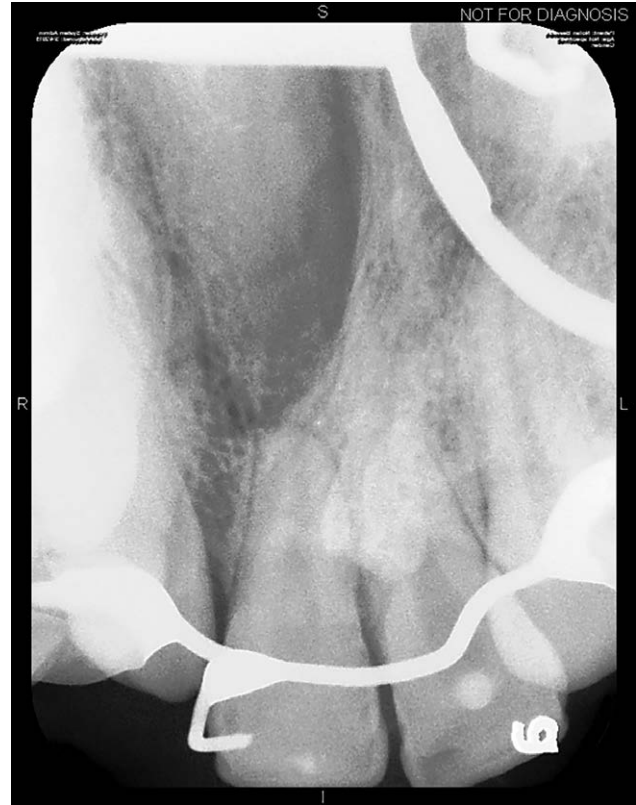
Periapical film demonstrating bone generation in both clefts 4 years after repair.
